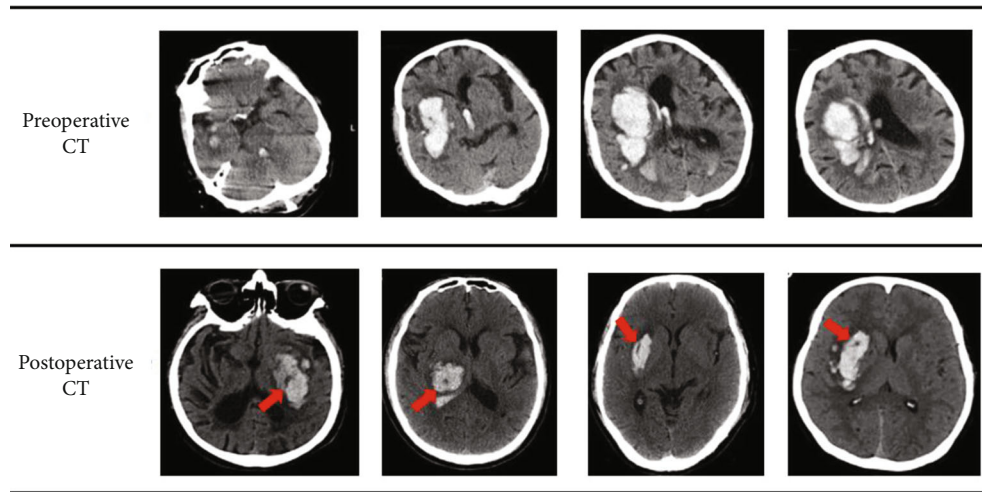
Head CT before and after surgery.
